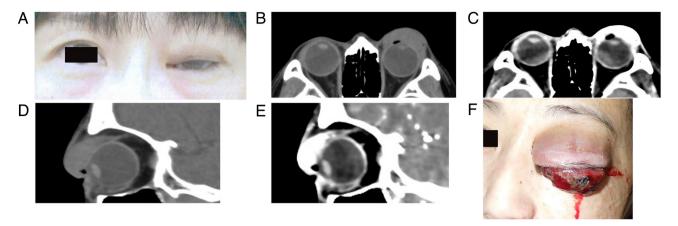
(A) External ocular presentation: Left eyelid swelling can be noted. (B) Unenhanced and (C) enhanced CT of the eye region in April 2023 by horizontal section, showing an eyelid tumor with marked intensity on enhancement. (D) Unenhanced and (E) enhanced CT in April 2023 by sagittal section, showing a mass lesion along with the superior rectus muscle and tumor invasion to the anterior orbit, respectively. (F) Just before exenteration, the left eyelid showed marked swelling with relentless bleeding. CT, computed tomography.
